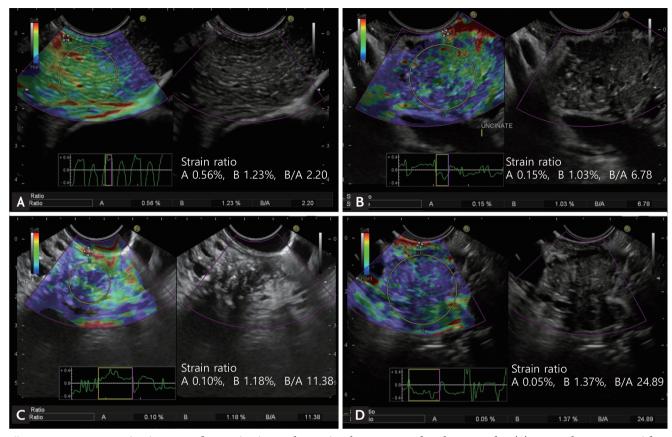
Representative images of quantitative endoscopic ultrasonography elastography. (A) Normal pancreas with a green-colored homogenous pattern (strain ratio, 2.20). (B) Early-stage chronic pancreatitis with a heterogenous pattern (strain ratio, 6.78). (C) Chronic pancreatitis with a heterogenous pattern (strain ratio, 11.38). (D) Pancreatic cancer with a blue-colored homogenous pattern (strain ratio, 24.89).
